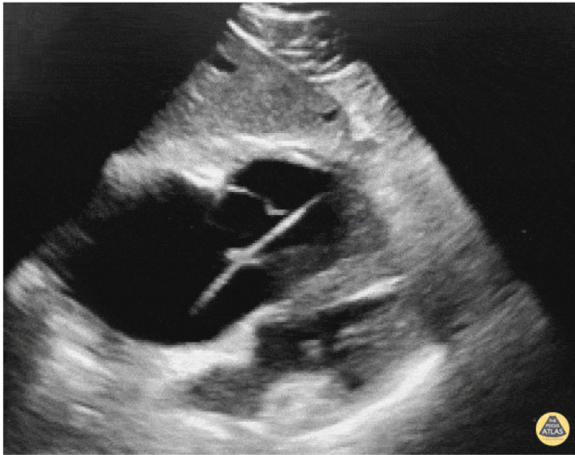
Point-of-care ultrasound showing transvenous pacemaker placement passing through the right atrium to the right ventricle. From The POCUS Atlas, reprinted with permission (26).
